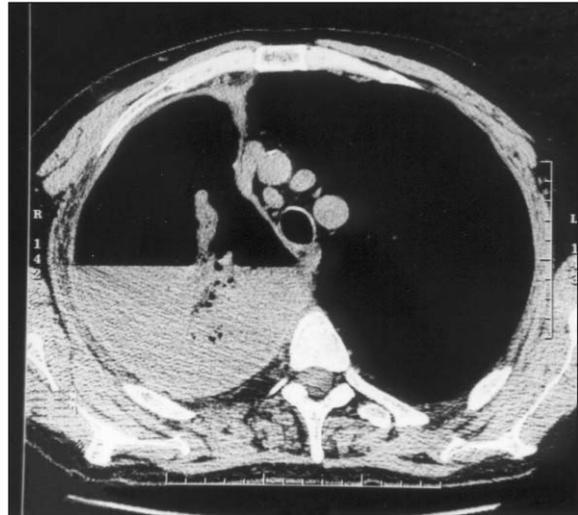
Thorax CT revealing abscess formation.
